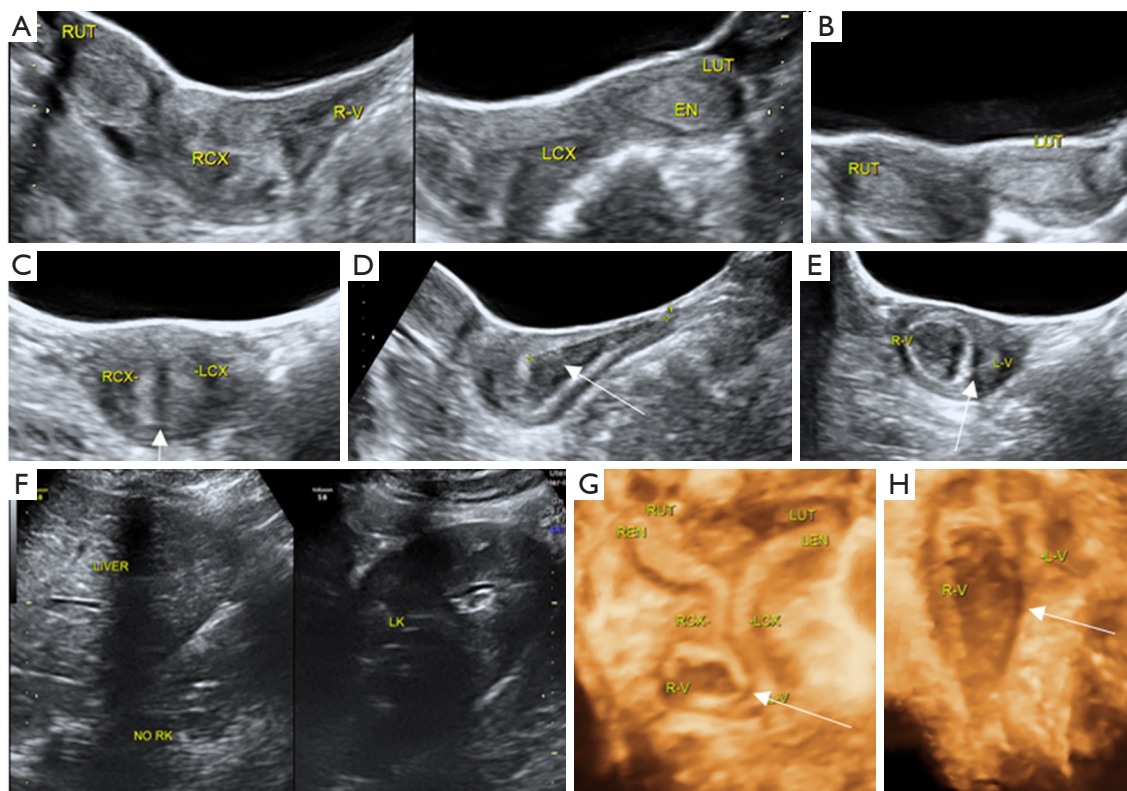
Type I-b UGTOIRA syndrome: U3b-C1-middle OVS, complete bicorporal uterus, septate cervix without cervical obstruction, with right-middle OVS (with a foramen on OVS observed intraoperatively), and right renal agenesis. Sonograms were obtained from a 14-year-old female patient. (A) TAS 2D sagittal pelvic planes demonstrating a normal right uterus and cervix, a small amount of hematocele in the posterior space of the OVS (left side of the figure), and a normal left uterus, cervix, and left vagina (right side of the figure). (B) TAS 2D cross-section of the uterus demonstrating a complete bicorporal uterus. (C) TAS 2D cross-section of the cervix demonstrating a septate cervix (the arrow indicates the septate). (D) TAS 2D sagittal plane of the right cervix-vagina demonstrating a small amount of hematocele in the posterior space of the OVS (the arrow indicates the blood accumulation). (E) TAS 2D cross-section of the middle part of the vagina demonstrating OVS with a small amount of hematocele in the posterior space of the OVS (the arrow indicates the OVS). (F) TAS 2D sagittal planes identifying the absence of the right kidney (NO RK; left side of the figure) and a normal left kidney (LK; right side of the figure). (G) TAS 3D coronal plane of the uterus-cervix-vagina under stereoscopy demonstrating a complete bicorporal uterus, septate cervix, and middle OVS with a small amount of hematocele in the posterior space of the OVS (the arrow indicates the OVS). (H) TRS 3D coronal plane of the cervix-vagina under stereoscopy demonstrating the septate cervix and OVS with a small amount of hematocele in the posterior space of the OVS (the arrow indicates the OVS). RUT, right uterus; RCX, right cervix; R-V, right vagina; LCX, left cervix; LUT, left uterus; EN, endometrium; L-V, left vagina; RK, right kidney; LK, left kidney; UGTOIRA, unilateral genital tract obstruction with ipsilateral renal anomaly; OVS, oblique vaginal septum; TAS, transabdominal sonography; 2D, 2-dimensional; 3D, 3-dimensional; TRS, transrectal sonography.
